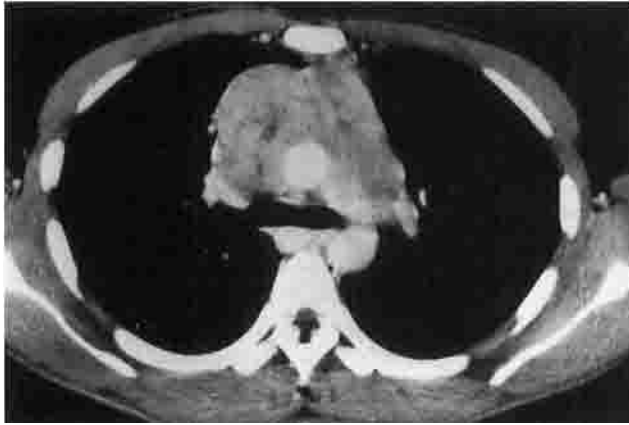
Chest CT findings of invasive thymoma in patient No. 12. Tumor involves the superior vena cava (SVC), aorta, and left pulmonary artery. Note that the SVC is almost occluded.
